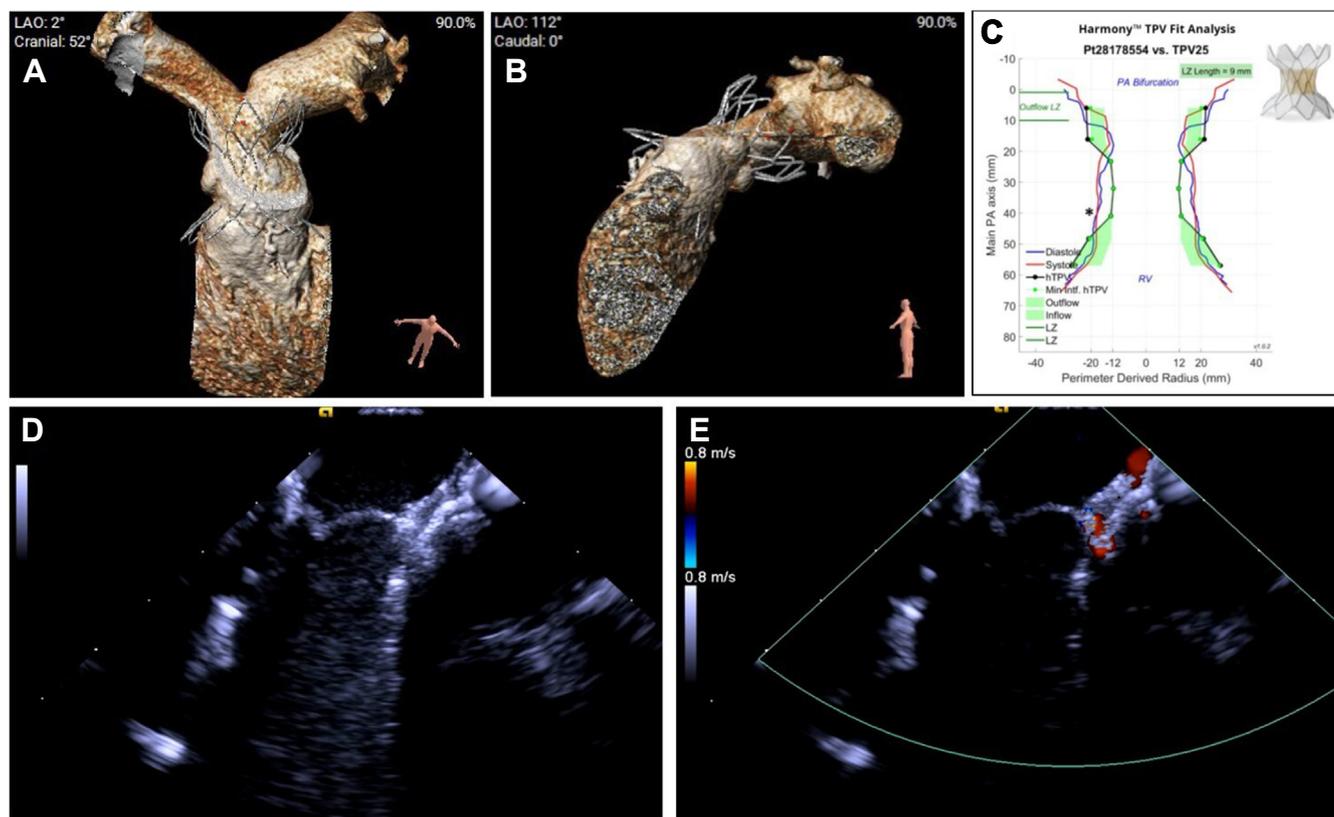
(A, B) Computed tomography 3-dimensional reconstruction of the right ventricular outflow tract (RVOT) to assess morphology and angulation as well as a Harmony TPV25 virtual valve in place to envision device fit. (C) Perimeter plot of the RVOT in both systole and diastole with the Harmony TPV25 valve dimensions superimposed within to assess device fit. (D, E) Intracardiac echocardiographic images showing excellent close proximity imaging of a newly deployed Venus P-valve with trivial paravalvular leak and no transvalvular leak. hTPV, harmony transcatheter pulmonary valve; LZ, landing zone; Min Intf, minimum interference; PA, pulmonary artery; RV, right ventricle; TPV, transcatheter pulmonary valve.
